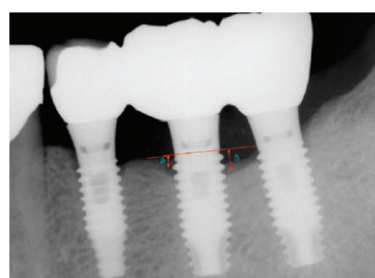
Periapical radiograph taken 1 year after implant placement. Based on the baseline, the crestal bone level on the radiograph taken immediately after surgery, from mesial side (a) and distal side (b), the vertical length to the first implant-bone contact area was measured and added by referring to the magnification rate and 0.8 mm pitch, and the average was obtained. In this case, a=0.8 mm and b=1.2 mm, and after 1 year; the mean amount of crestal bone resorption was 1.2 mm.
